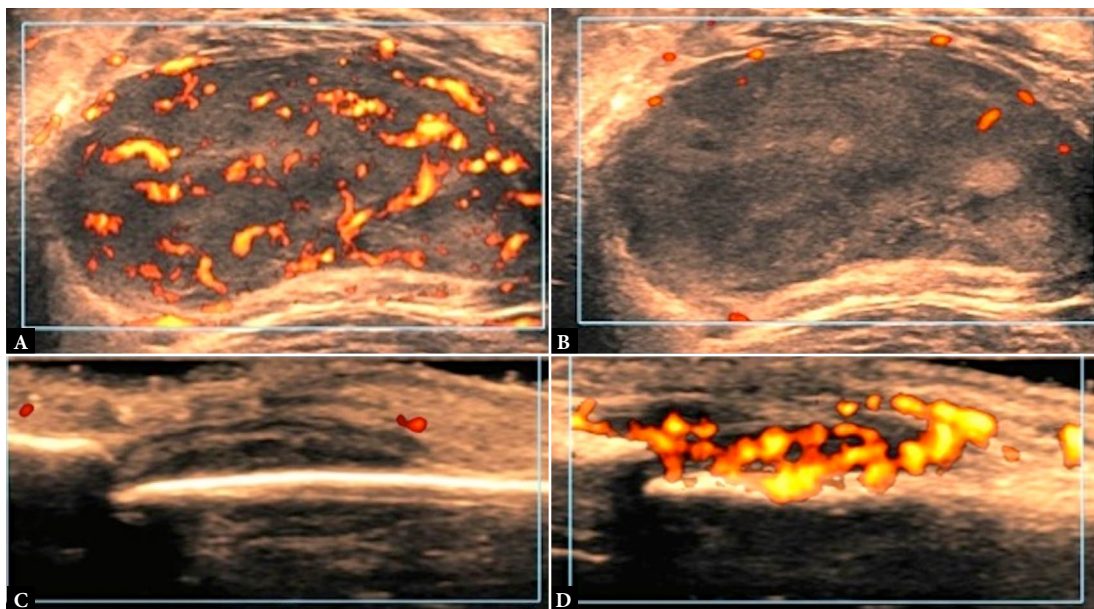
Power Doppler (PD) ultrasound image (B) and microvascular flow (Slow Flow™) image (A) of a soft tissue sarcoma within the rectus femoris muscle using identical Doppler parameters. Significant improvement in sensitivity and vascular morphology without blooming artifact is evident in the microvascular flow image. The mass appears hypovascular on PD, whereas the Slow Flow image depicts a hypervascular mass. C. Patient with swollen left 3rd PIP joint and history of psoriasis. PD (left) and Slow Flow image (right) long-axis views of the dorsal recess. There is mild distension of the dorsal capsule by hypoechoic soft tissue. Minimal periarticular vascularity is depicted on PD. D. On Slow Flow, there is marked synovial and periarticular hyperemia
